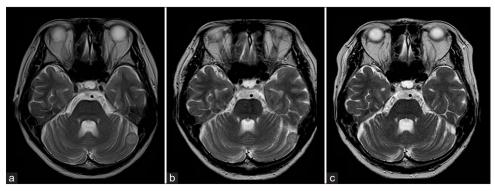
T2-weighted MR images taken 4 years (a), 8 years (b), and 12 years (c) after the initial diagnosis, showing gradual regression from $1.4 \text{ cm} \times 1.3 \text{ cm} \times 1.0 \text{ cm} \times 1.0 \text{ cm} \times 0.9 \text{ cm}$.
